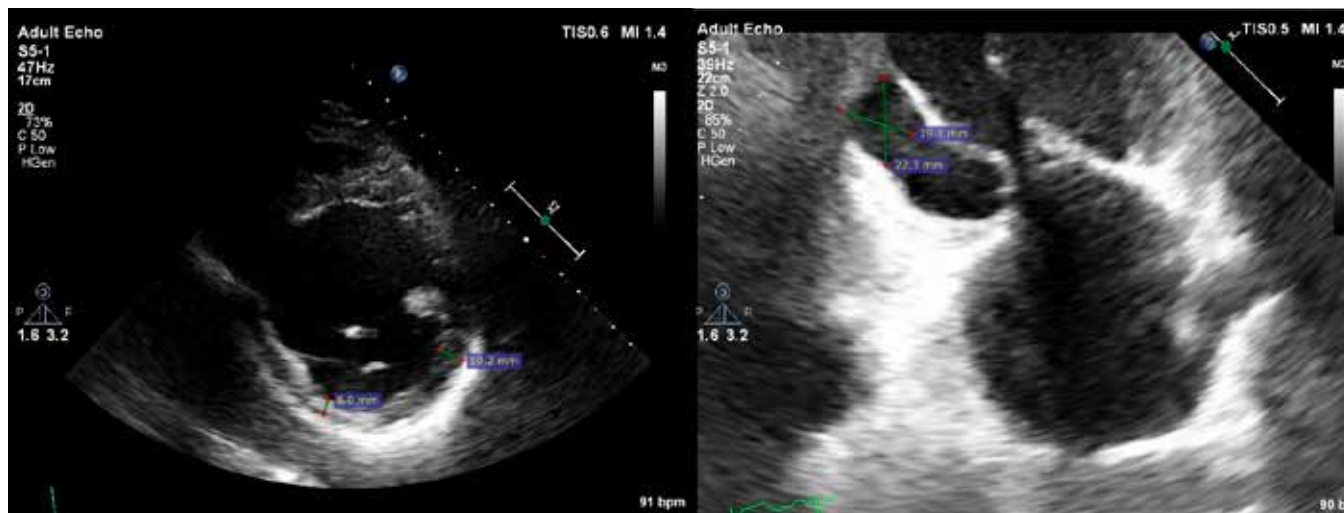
Transthoracic echocardiography – parasternal short axis view (left), apical two-chamber view (right). Post-infarct cardiac remodeling – a true aneurysm of the inferior wall (size 22x19 mm, arrow), thin and akinetic posterior wall, restriction of the posterior mitral leaflet. LA- left atrium; LV- left ventricle
